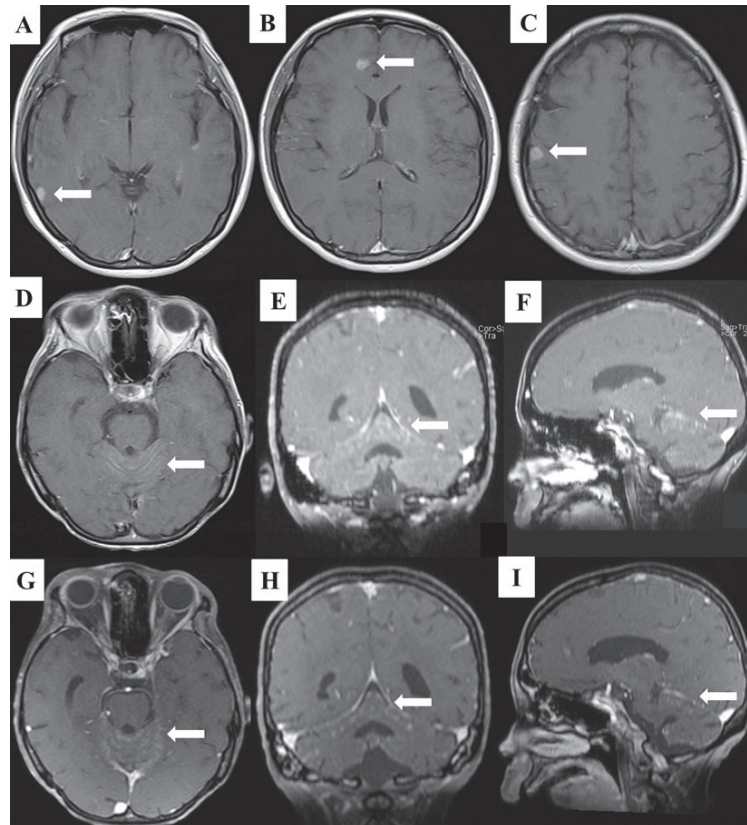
The status of BM and LM lesions before and after IP. (A-C) Brain MRI with contrast on July 4, 2018, revealed multiple metastatic brain lesions located in the bilateral cerebral and cerebellar hemispheres (as indicated by the white arrows). (D-F) Brain MRI with contrast on September 13, 2021, showed the onset of LM (as indicated by the white arrows). (G-I) Brain MRI with contrast on August 12, 2022, showed stable LM lesions (as indicated by the white arrows) after 9 courses of IP. BM, brain metastases; LM, leptomeningeal metastasis; IP, intrathecal chemotherapy with pemetrexed; MRI, magnetic resonance imaging.
